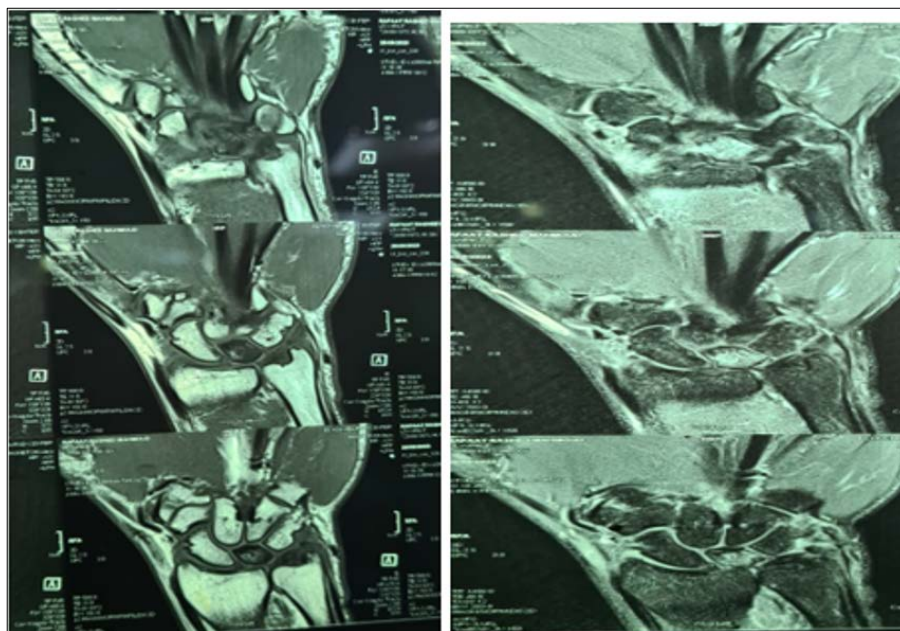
Pre-operative MRI showing Kienbock type II.
